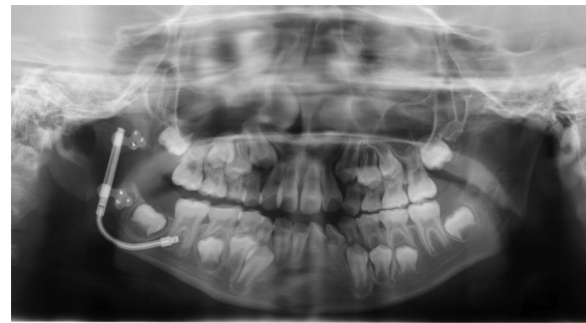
Panorama X-ray after elongation was achieved.
